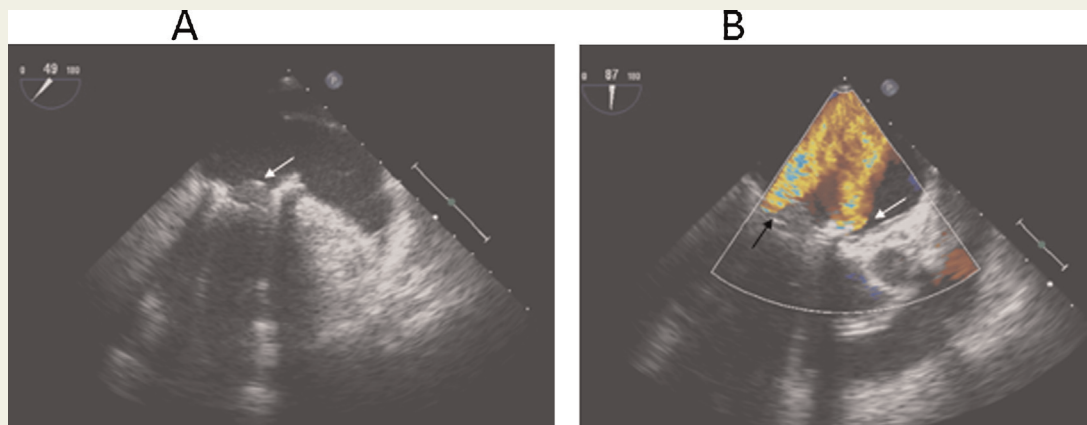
(A) Transoesophageal echocardiogram showing ball cage mechanism (white arrow). (B) and movie 1 – transoesophageal echocardiogram with colour Doppler (white arrow representing para-prosthetic regurgitation and black arrow pointing at intravalvular regurgitation)
